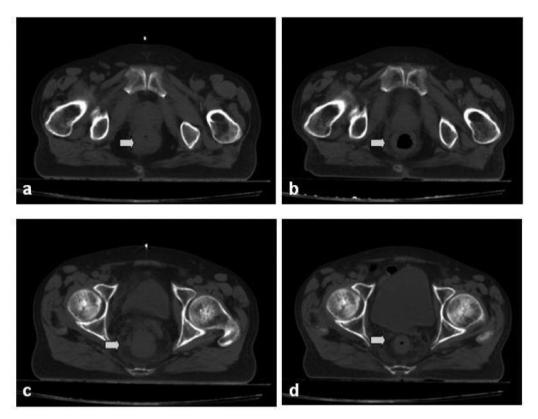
CT-imaging of two rectal adenocarcinomas (a and c) before starting concurrent accelerated capecitabine radiochemotherapy. Marked response with opening of the obstructed lumen (b) and normalization of the perirectal tissue (d) one month after the completion of the preoperative regimen.
